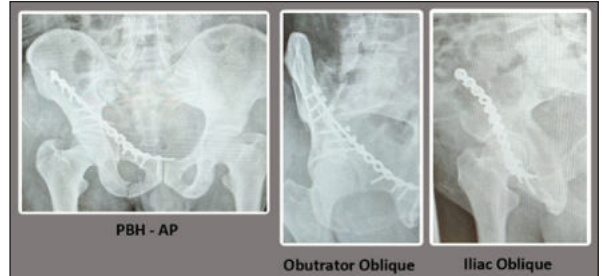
Post-operative Radiographs In The Anteroposterior And Oblique Views
